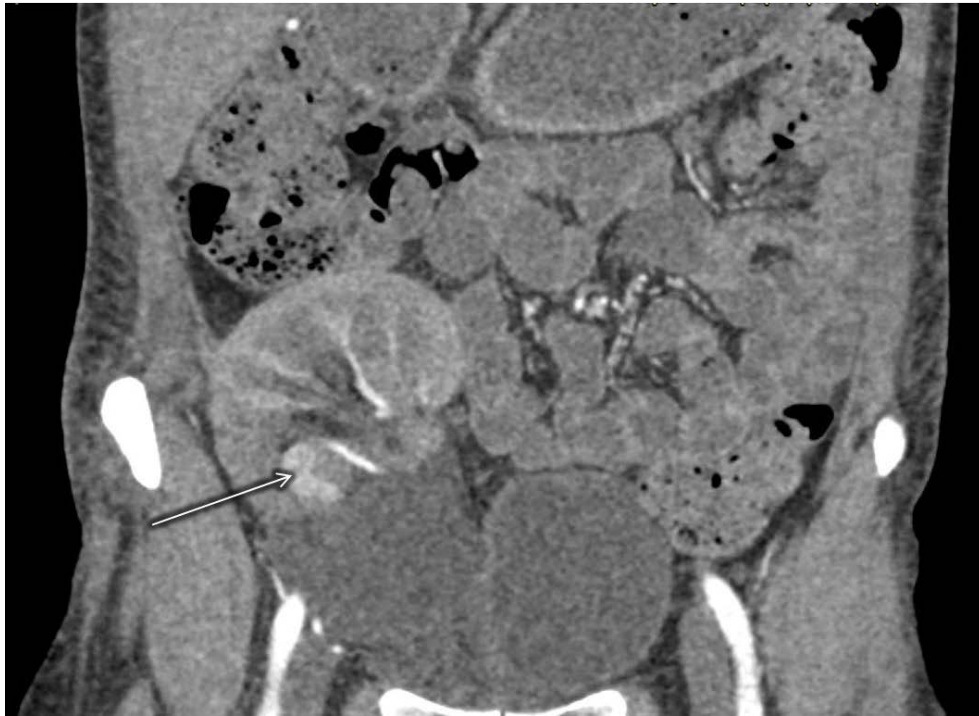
Multislice spiral computed tomography of the pelvic organs and retroperitoneum with intravenous contrast. False aneurysm of the interlobar renal artery, retroperitoneal lymphocele (the arrow indicates a false aneurysm 24×10 mm)
